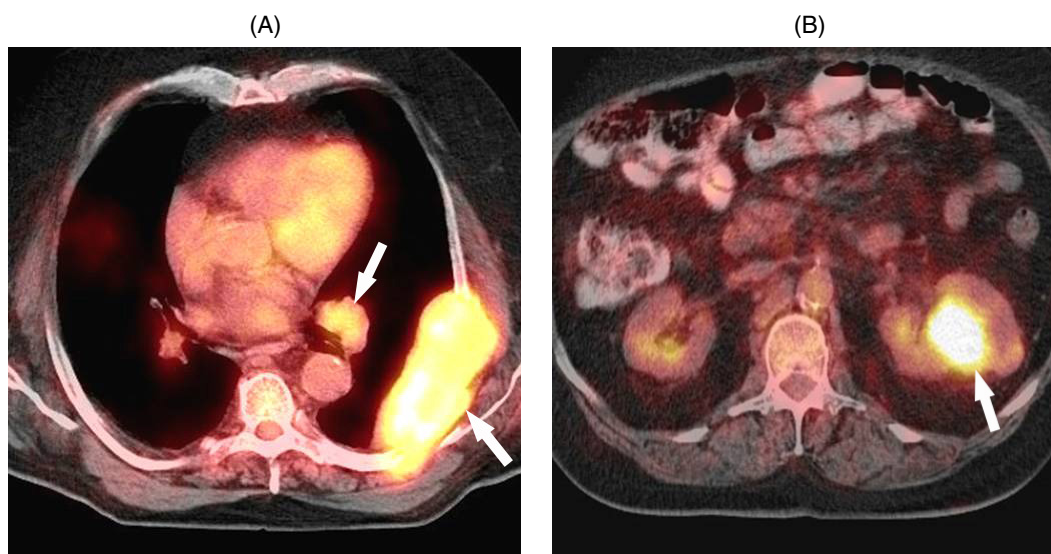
Fused PET-CT image (A) demonstrates metastatic disease to the left hilar lymph node and chest wall (arrows) as well as the primary tumor (B) in the left kidney (arrow).
